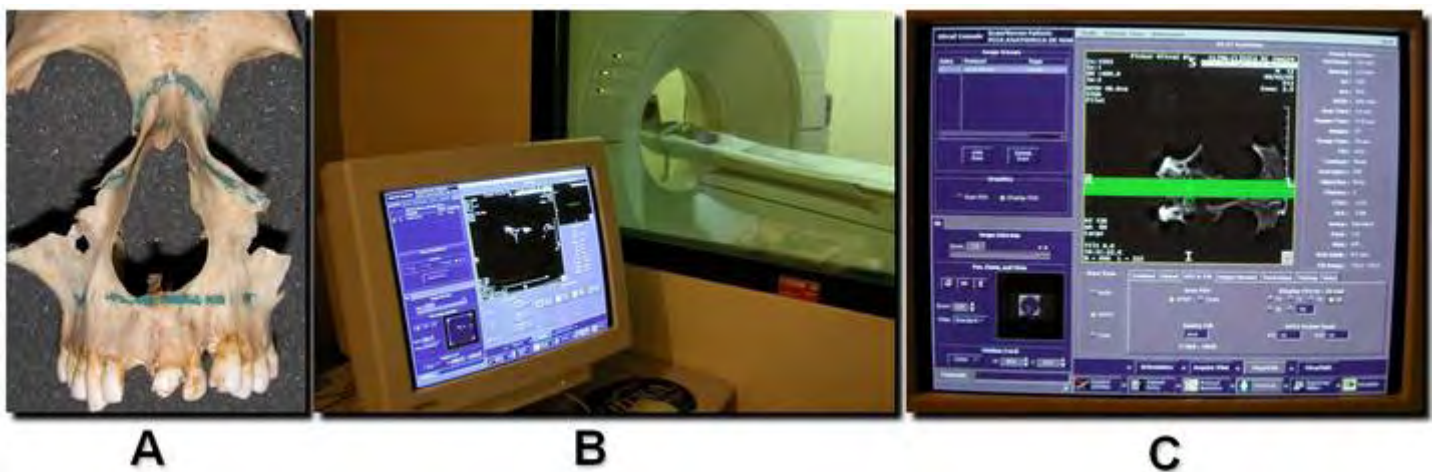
A – Dry maxilla. B, C – Acquisition of CT images of an extraction socket of the dry maxilla.
